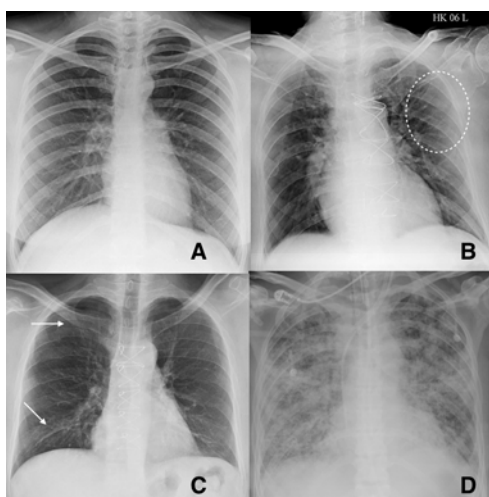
CXR's of different patients with proven COVID-19 demonstrating varied appearances at the time of presentation. A- No abnormalities could be seen on CXR and the corresponding CT (not shown) was also near normal. B- Ill-defined hazy peripheral opacities seen in the left upper zone. C- Multifocal opacities were seen in the right lung on CXR at presentation. D- CXR showing extensive parenchymal infiltrates in a patient who came to the hospital in very bad respiratory distress and was found to have COVID-19 on testing.
